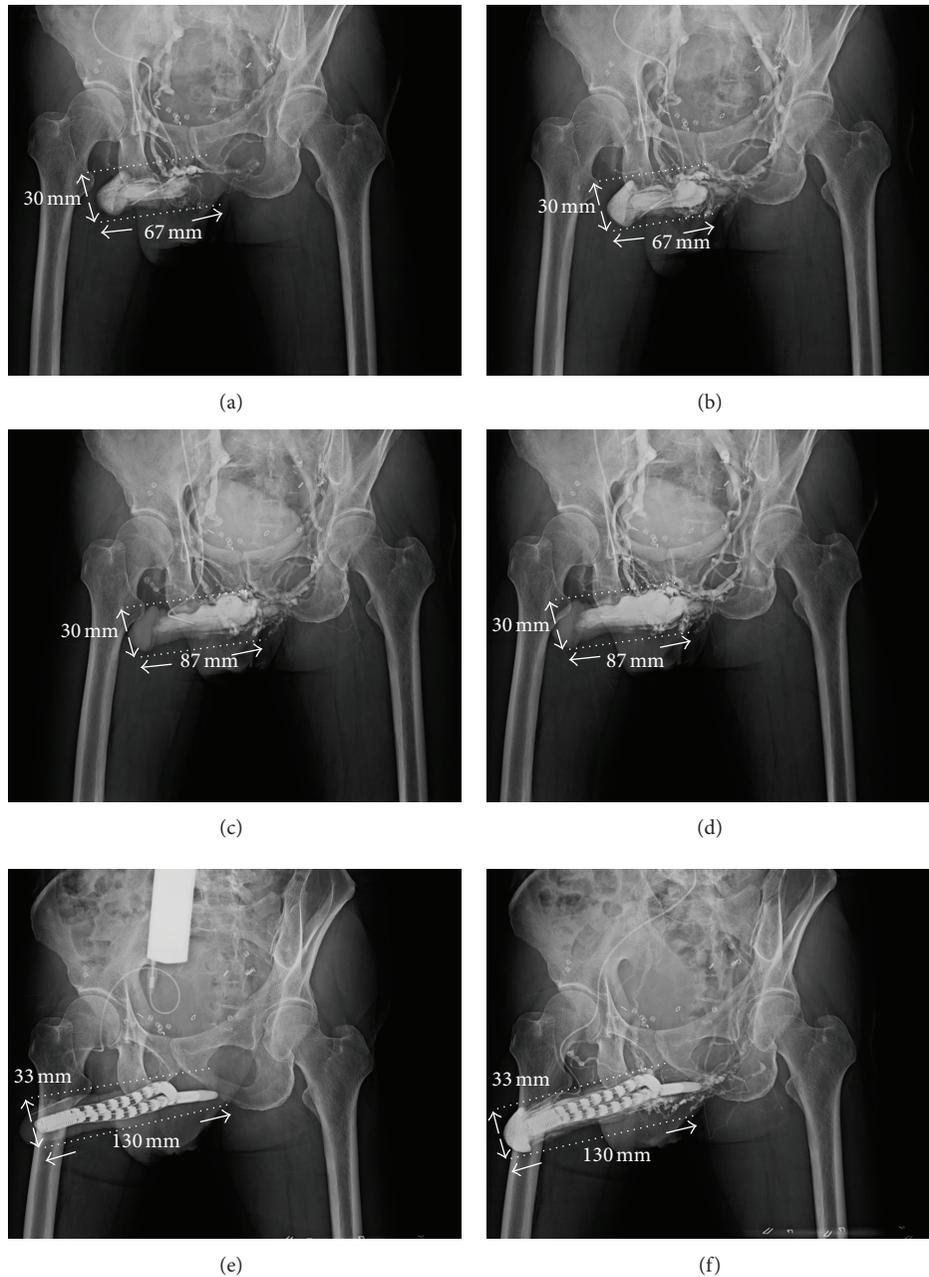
Pelvic X-ray film of 30° oblique view of a 77-year-old male of traumatic impotence. He underwent cryosurgery for prostate adenocarcinoma in 2010. (a) Caverosogram was made after 20 mL of contract medium was injected. (b) Caverosogram was undertaken after another 30 mL of contract medium was injected. (c) The penile tissue could not extend 30 min after 20 μ g prostaglandin E1 (PGE1) was intracavernously injected. The venous leakage was shown because the drainage veins are conspicuous despite an intracavernosal pressure which exceeded 110 mmHg. (d) The situation was reassured. (e) The venous surgery was performed for penile enhancement in addition to regular penile implant. The penile length was increased although the glandular radius changed from 30 mm to 33 mm. This situation is confirmed (f).
